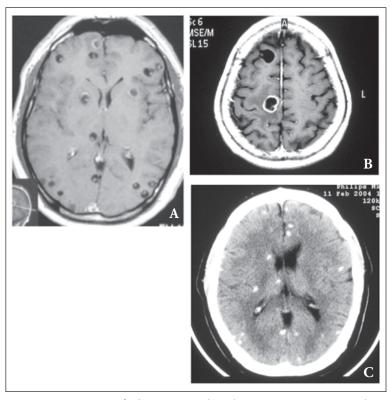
Neuroimaging findings in parenchymal neurocysticercosis: A) CT showing vesicular cysts appearing as well-defined cystic lesions with scolex; B) T2-weighted MRI showing a colloidal cyst visualized as a ring-enghaninc lesion surrounded by edema; and C) CT showing multiple small calcifications.
